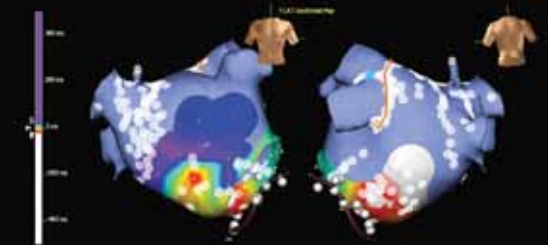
Cardiac CT image of the left atrium and pulmonary veins after 3D reconstruction, mapping, and ablation of atrial fibrillation. This patient underwent pulmonary vein isolation as well as ablation of both left atrial tachycardia and flutter.
